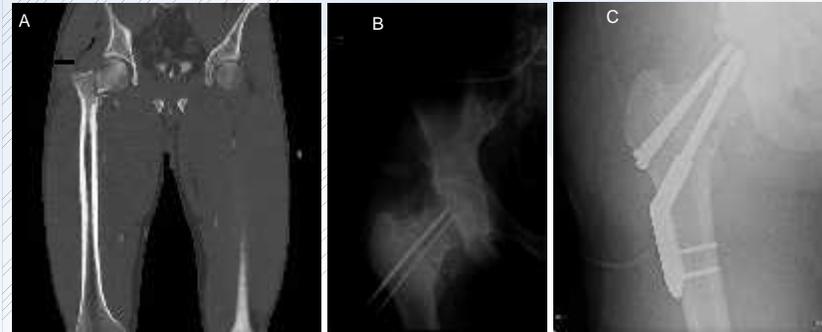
Demonstrates A: CT scan post-injury of patient 1 with femoral neck fracture, B: provisional fracture fixation, C: definitive fracture fixation.
